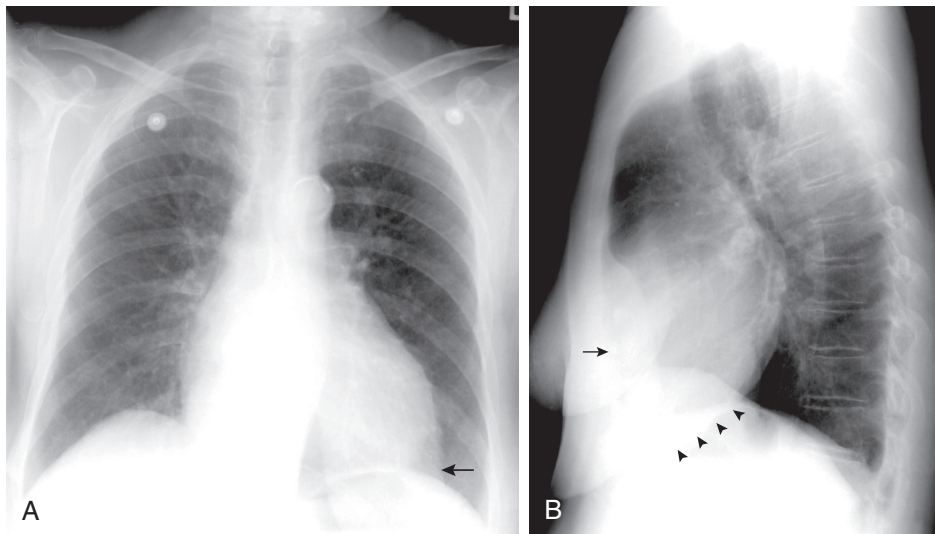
FIGURE e15-4 Chest radiographs of a 70-year-old woman with rheumatic heart disease and combined aortic stenosis and mitral stenosis. Her PCWP is 30 mm Hg. A, PA view. There is evidence of chronically elevated pulmonary venous pressure with moderate (not marked) pulmonary vascular redistribution. Moderate LV enlargement and prominence of the LA appendage are present. B, Lateral view. Note enlargement of the left ventricle, which is extending below the diaphragm and compressing the gastric bubble (arrowheads). Also note the apical fat pad, seen as the hazy density on the frontal view (A, arrow) and as the anterior, retrosternal, well-delineated, wedge-shaped density on the lateral view (B, arrow).
